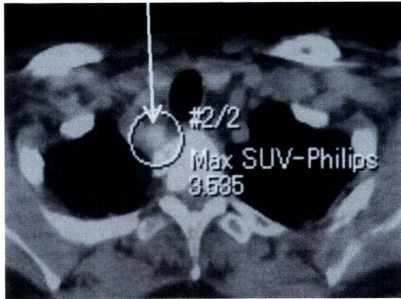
FDG-PET/CT of the patient shown in Fig. 1 performed during the same period demonstrated high uptake of FDG ($SUV_{max} = 3.5$) within the right upper paratracheal node (arrow). This site was interpreted malignant and this FDG-PET/CT study was interpreted as positive. Radiologic follow-up analyses revealed that this case was true positive for the FDG-PET/CT study and radiation therapy was performed. FDG-PET/CT, F18-fluorodeoxyglucose positron emission tomography-computed tomography; SUV, standard uptake value.
